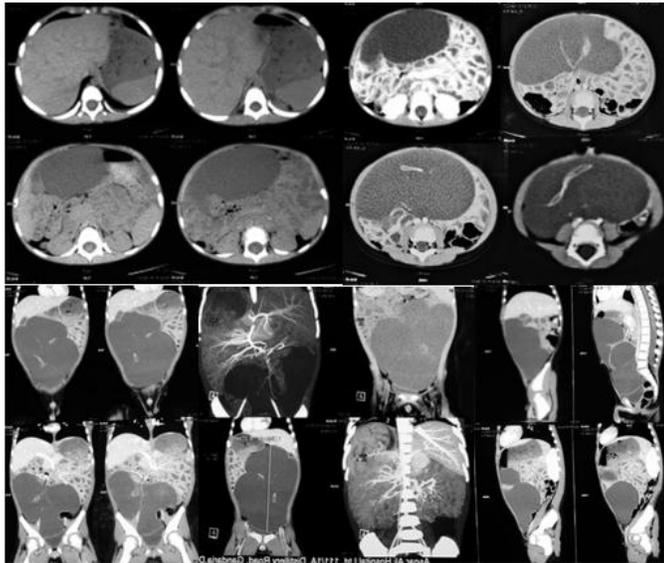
CT scan of abdomen showing mesenteric cysts. (N=55)
